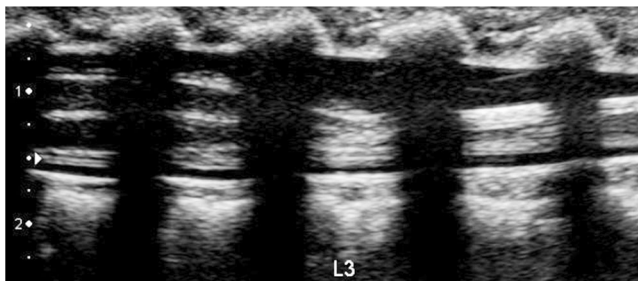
Sonogram of a 2.5-month-old girl shows an isolated low conus, terminating at the mid-body of L3
